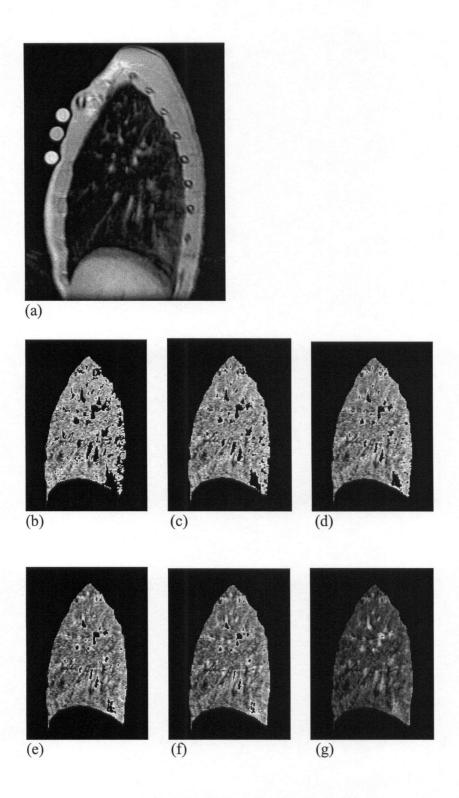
(a) Sample MR image of right sagittal lung slice. (b) - (g): Computerized image of the lung scan showing areas of pixel removal. Dark areas within the lung represent areas of pixel removal using a threshold of (b)  $0.25~\rm g\cdot mL^{-1}$  (c)  $0.3~\rm g\cdot mL^{-1}$  (d)  $0.35~\rm g\cdot mL^{-1}$  (e)  $0.4~\rm g\cdot mL^{-1}$  (f)  $0.45~\rm g\cdot mL^{-1}$  (g)  $1.0~\rm g\cdot mL^{-1}$ .
